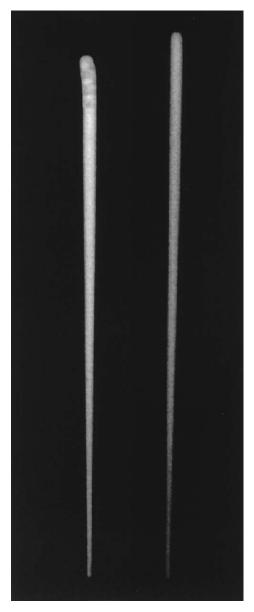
Radiographic comparison of gutta percha cones size 30, 0.02 taper from Caulk Densply ISO noncolor (*left*) and MicroSeal (*right*).
